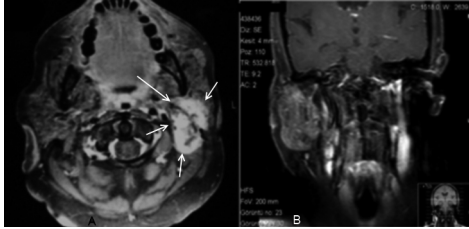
A) Axial MRI view shows the tumor originating from the left parotid region (white arrows), B) T1-weighted gadolinium-enhanced magnetic resonance imaging of the patient's neck shows that not distinguish in favor of recurrent contrast enhancement in the left parotid region.
